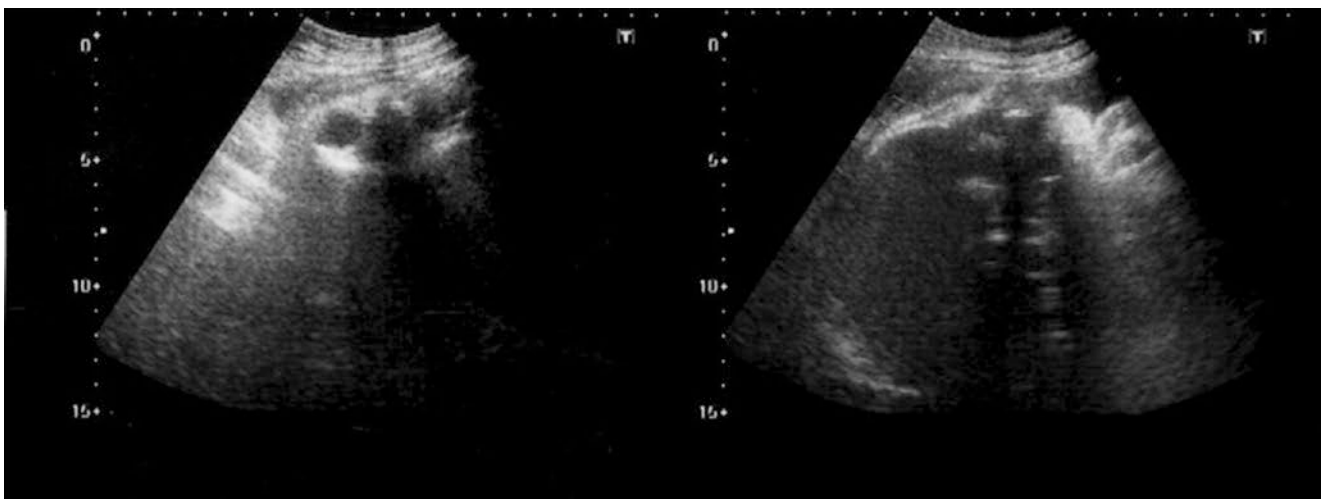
Transabdominal transverse ultrasonographic section of the fetal head in linear occiput posterior position (anterior orbits and nasal bridge), on the left. Asymmetric fetal profile in transabdominal
